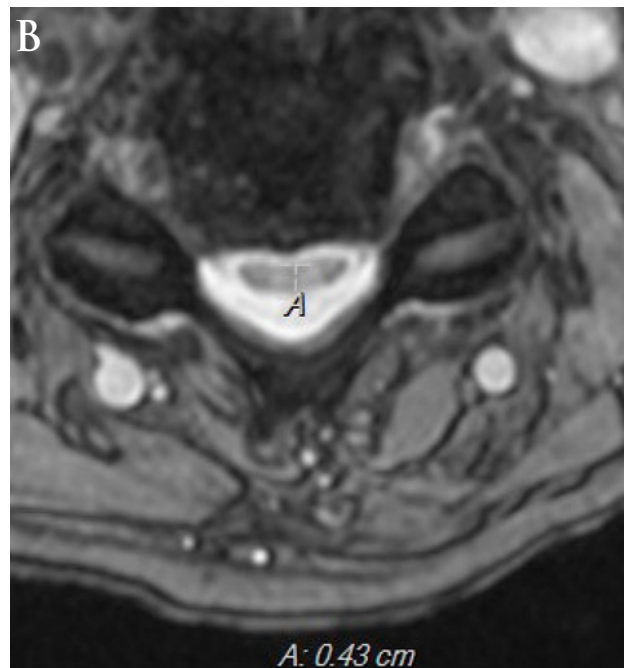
Case 1's MRI of the cervical spine
